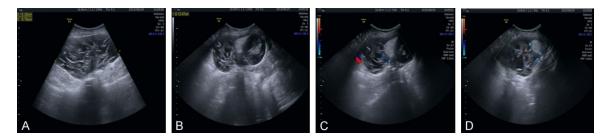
A and B. B ultrasound showed: Pelvic cystic tumors cystadenoma? Teratoma be ranked pelvic fluid, see a cystic mass about the size of $132 \times 68 \times 125$ MM of pelvic, intracapsular see many separate samples and floculent echo, intracapsular see a hyperechoic size of about 32×25 MM nodules; C and D. CDFI: no abnormal blood flow in the uterus color display.
